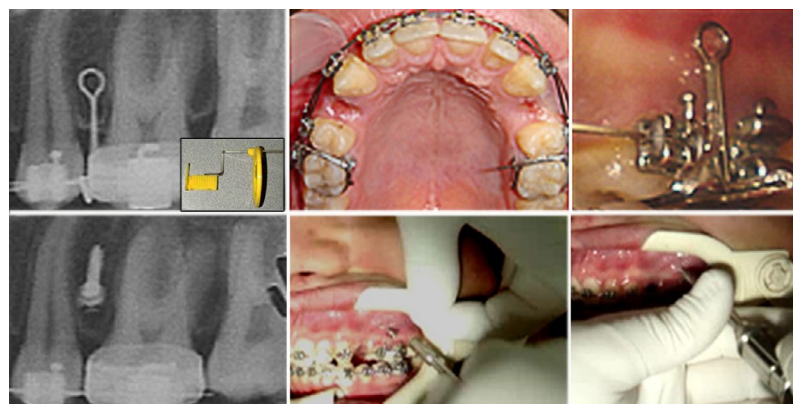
Wire guides and periapical radiographs (depending on paralleling technique for dental radiography) were been used to put
